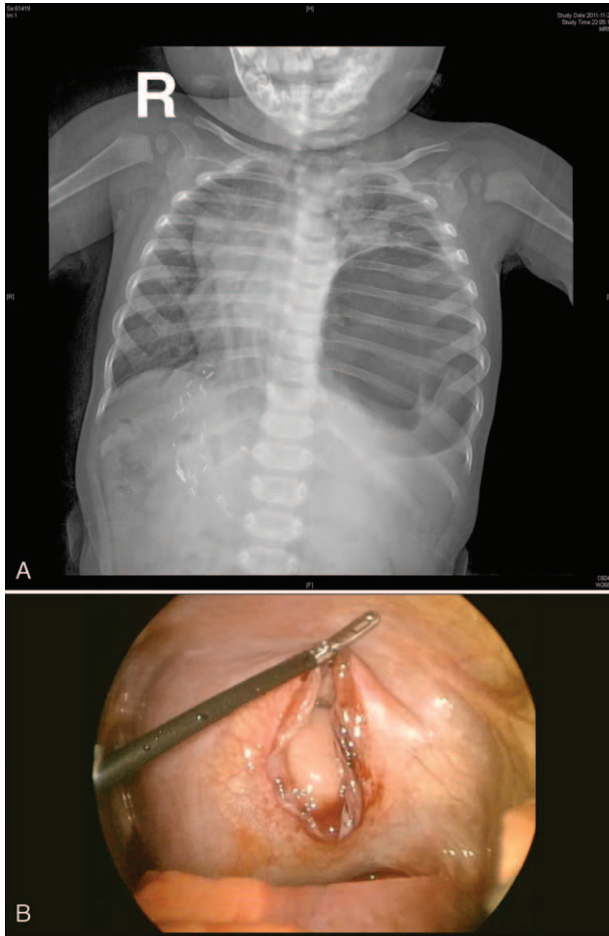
(A) Chest X-ray showing a large abnormal air density in the left lower thorax and (B) thoracoscopic view of the left diaphragmatic defect with the stomach reduced into the peritoneal cavity in Case 1.
